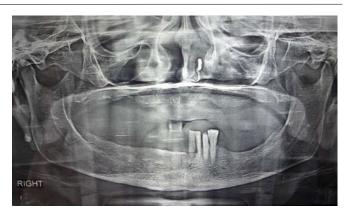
Case1: A panoramic radiograph showing loss of all teeth in maxilla and multiple loss of teeth in mandible with variable amount of bone loss
